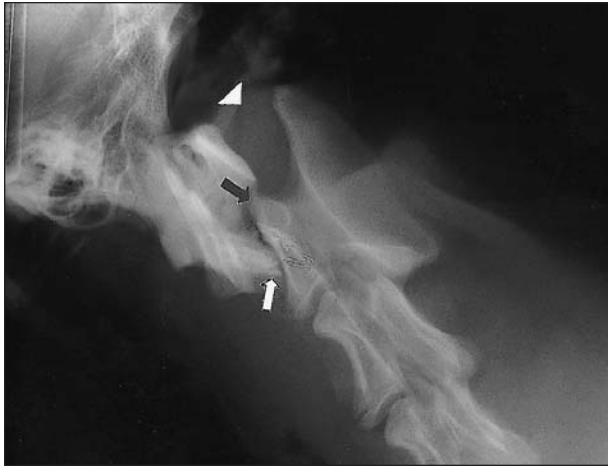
Same radiographic view as in Figure 1. The odontoid process is fractured away from the axis (black arrow), but remains attached to the body of the atlas (white arrow). Notice the step malalignment of the vertebral canal between the atlas and the axis (arrowhead).
